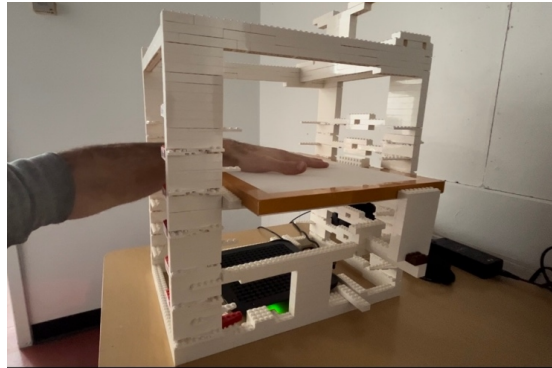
This figure displays the hardware apparatus used by the participant to receive the ultrasonic haptic signal.
